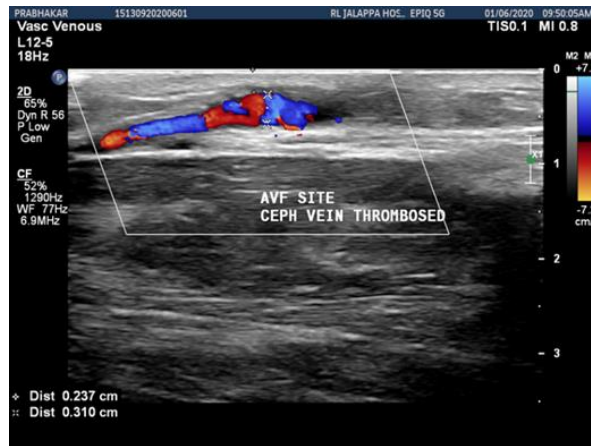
Colour Doppler ultrasound image showing venous thrombosis close to the site of AVF
